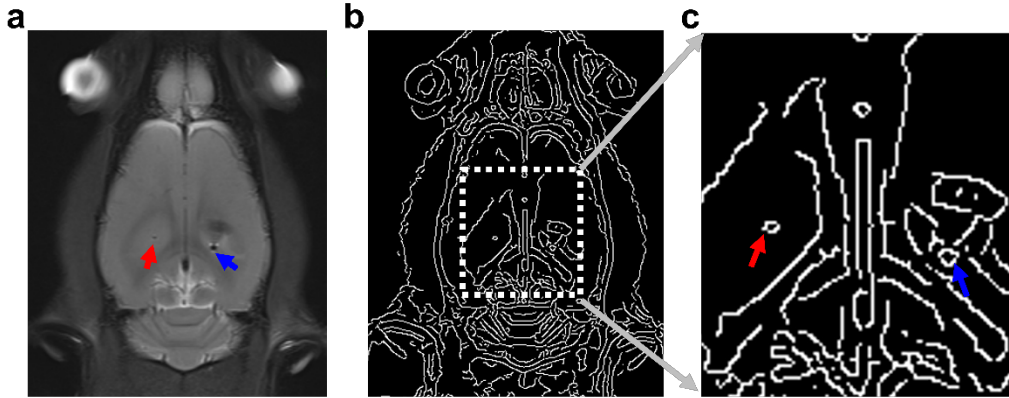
An example demonstrating the measurement of the artifact size in MRI. (a) This is the original MRI image used in the demonstration for measuring artifact size. The red arrow points to the CNT fiber and the blue arrow points to the PtIr electrode. (b) The generated edge image of the original image with Canny edge detector in Matlab (Mathworks, USA). (c) An enlarged image of the white dotted frame in b with the same color code used as in a. The white enclosed area indicates the artifact. The size of an artifact is defined as the equivalent diameter of a circle with the same geometrical area.
